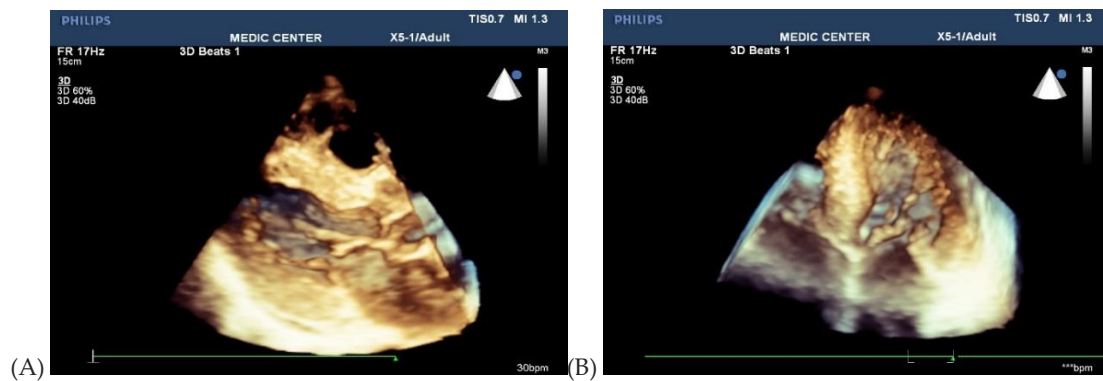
A: Live 3D of parasternal LAX showed LV hypertrophy and irregular echodensity of myocardium. B: Live 3 D of apical 4C view provided LV hypertrophy and irregular density of IVS.
